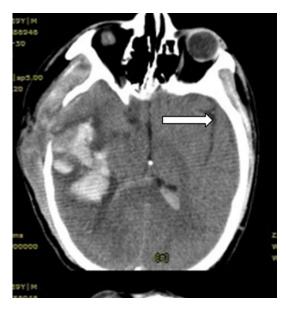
The CT after EVT showed no new hemorrhages, the brain edema reduced, and the lateral fissure (white arrow) can be seen clearly than before.
